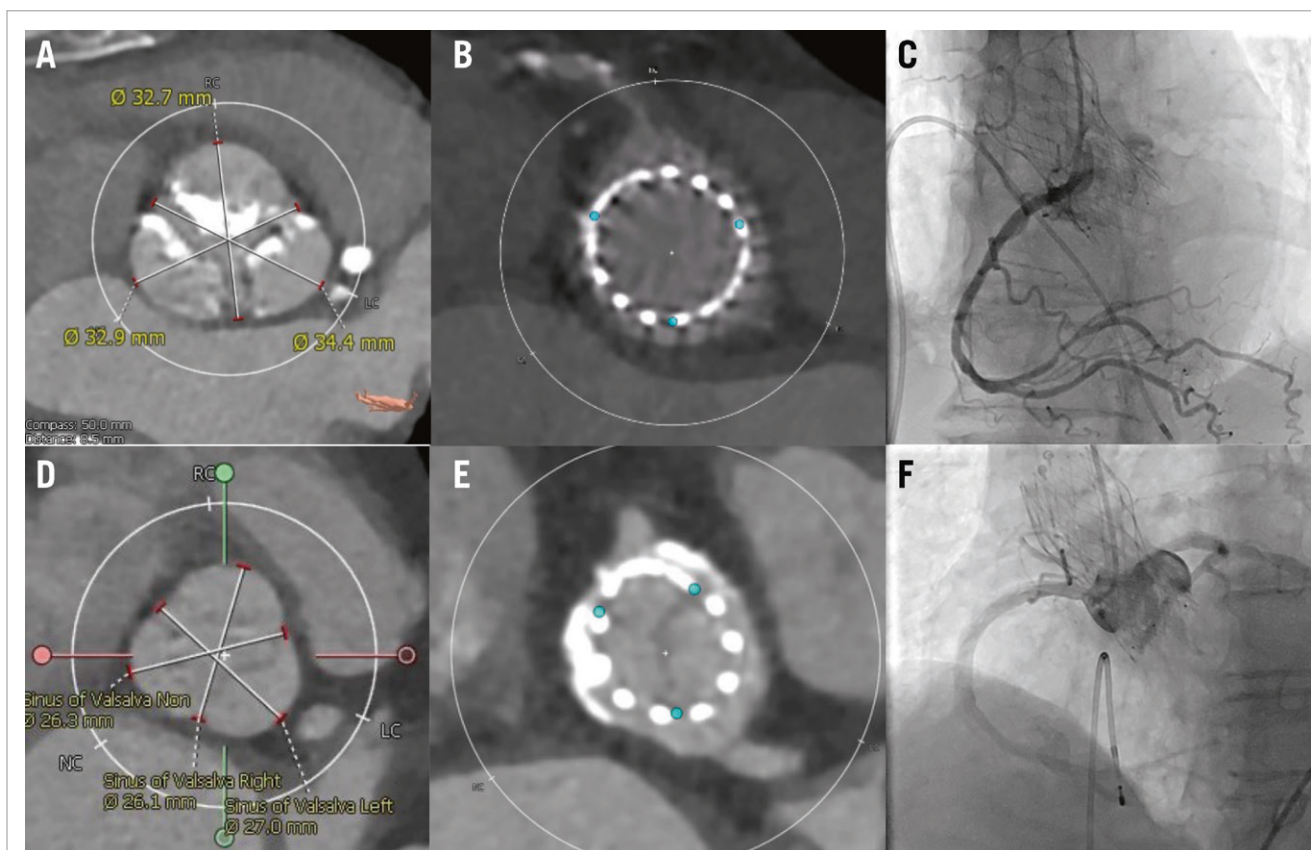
Post-TAVI CT showing favourable and unfavourable RCA cannulation. This figure shows post-TAVI CT which shows favourable (A-C) and unfavourable (D-F) anatomy for RCA cannulation. A) Wide sinus of Valsalva, (B) space between the Evolut FX 29 mm and the coronary ostium, (C) selective coronary cannulation achieved. D) Narrow sinus of Valsalva, (E) limited space between the Evolut FX 26 mm and the coronary ostium, (F) non-selective coronary cannulation. CT: computed tomography; RCA: right coronary artery; TAVI: transcatheter aortic valve implantation
